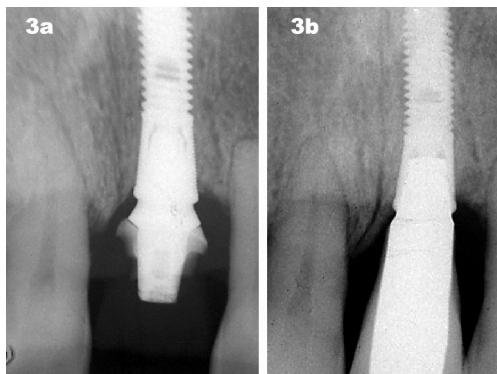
X-ray at the time of placing the fixture and the provisional crown.
